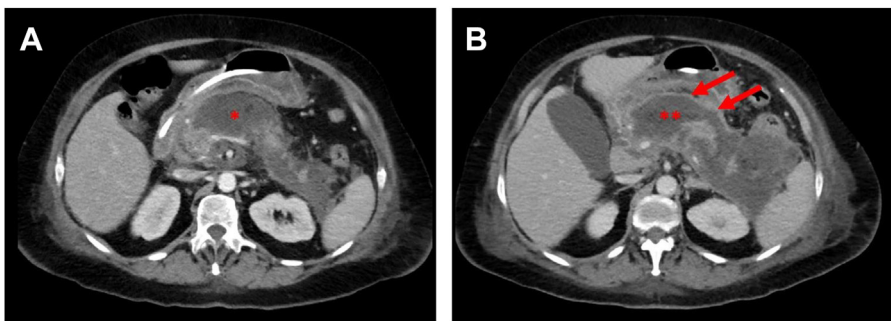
Contrast-enhanced computed tomography at 2 weeks (A) and 2 months (B) in a patient with necrotizing pancreatitis. Note the transition from an ANC (*asterisk*) to walled-off necrosis (*double asterisk*) characterized by the development of a well-defined inflammatory wall of reactive tissue (*arrows*).
